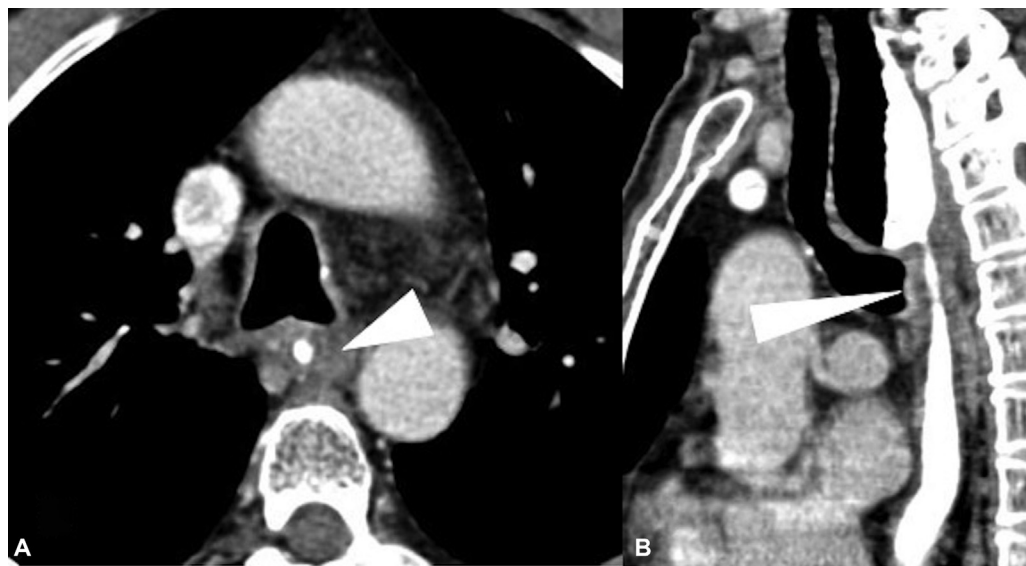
(A and B) Case of squamous cell carcinoma of the middle third of the esophagus, postneoadjuvant chemoradiotherapy, presented with increasing dysphagia. Brush cytology was negative for malignancy. Axial (A) and sagittal (B) computed tomographic images show a short segment smooth circumferential wall thickening (arrowhead), with proximal esophageal dilatation.
